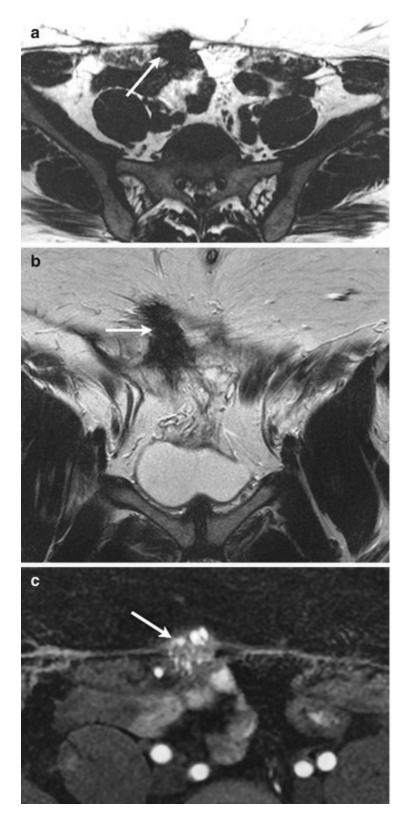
A 35-year-old woman with a parietal mass: Parietal endometrioid in the right rectus abdominis muscle. MRI shows recent hemorrhagic changes in subcutaneous tissue and the abdominal wall (arrow) with low signal intensity on T1-weighted images (a), heterogeneous signal on T2-weighted images (b) and significant enhancement after gadolinium injection (c).
